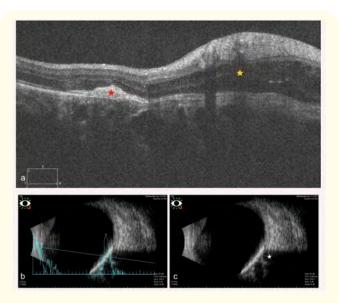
(a-c): (a) Spectral Domain OCT of Right eye showing hyper-reflective CNVM complex (yellow star), with intra-retinal fluid (red star). (b,c) A scan ultrasound scan showing a high intensity echo spike from inner surface of the tumor; B scan showing elevated, linear membranous high amplitude echogenicity with post acoustic shadowing that giving an appearance of "pseudo-optic nerve" (white star).
